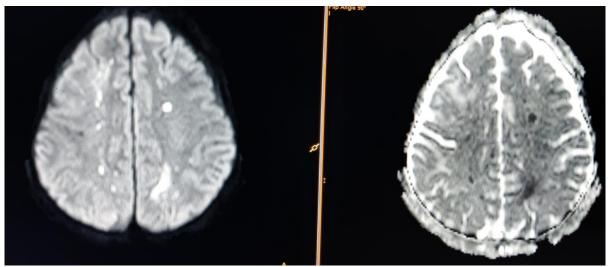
Axial DWI and ADC images showing above mentioned T2/FLAIR hyper intensities showing DWI restriction.
